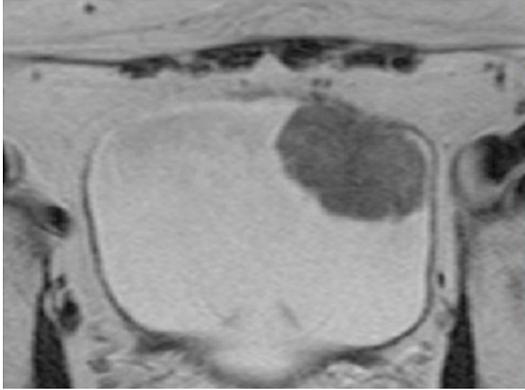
MRI imaging scan of the patient showing a tumor, measuring 43 mm in the bladder dome.
